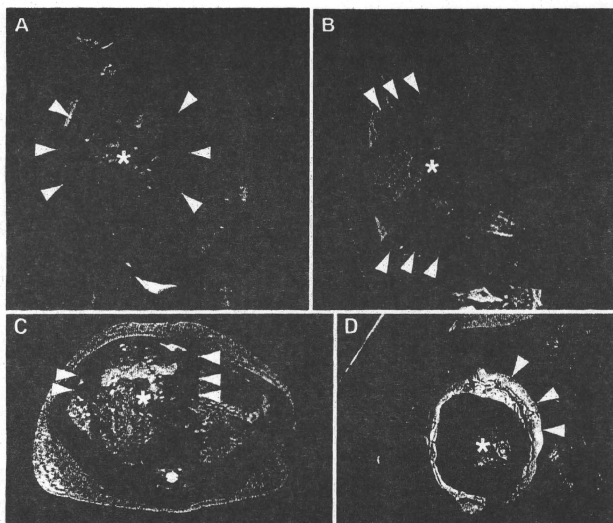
A-C: Abdominal MRI after the operation for spacer placement. D: The spacer around the tumor using Gore-Tex sheets. The arrowhead shows the spacer around the tumor, and it maintained a sufficient open space between the tumor and the intestine. The asterisk shows the tumor.
